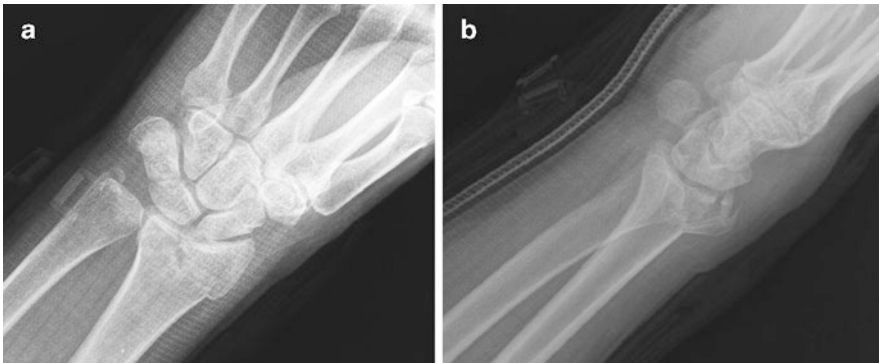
(a) AP radiograph wrist (b) Lateral radiograph wrist
